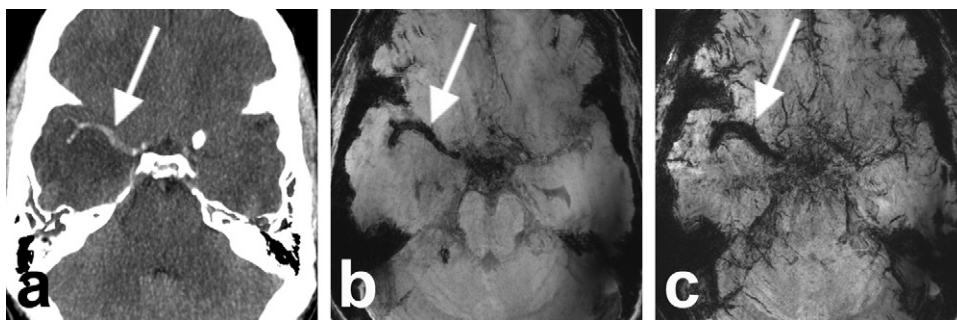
42-year-old man with blank medical history presented with searing headache and thereafter hemiparesis of the left arm and leg, based on an ischemic infarction of the right middle cerebral artery (MCA)-territory. a, Axial CT-image showing slightly hypodense signal of the right temporal lobe, as well as a hyperdense vessel sign (arrow) of the right MCA. b, Axial minMIP (over 10 mm thick volume) of the 1st and c, the 2nd echo of 7 T T_2^* -weighted images, visualizing thrombotic material in the right MCA (arrows). Due to the very short T_2^* of thrombus, it can already be seen on the 1st echo minMIP (b). Imaging parameters of the 7 T T_2^* -sequence as previously published [33].
